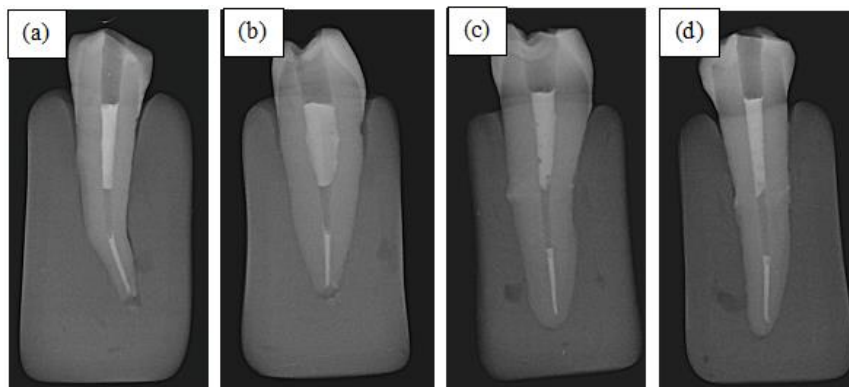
Obturation radiographs in continuous backfill (a) mesio-distal angle, (b) bucco-lingual angle, and interrupted backfill (c) mesio-distal angle and (d) bucco-lingual angle
